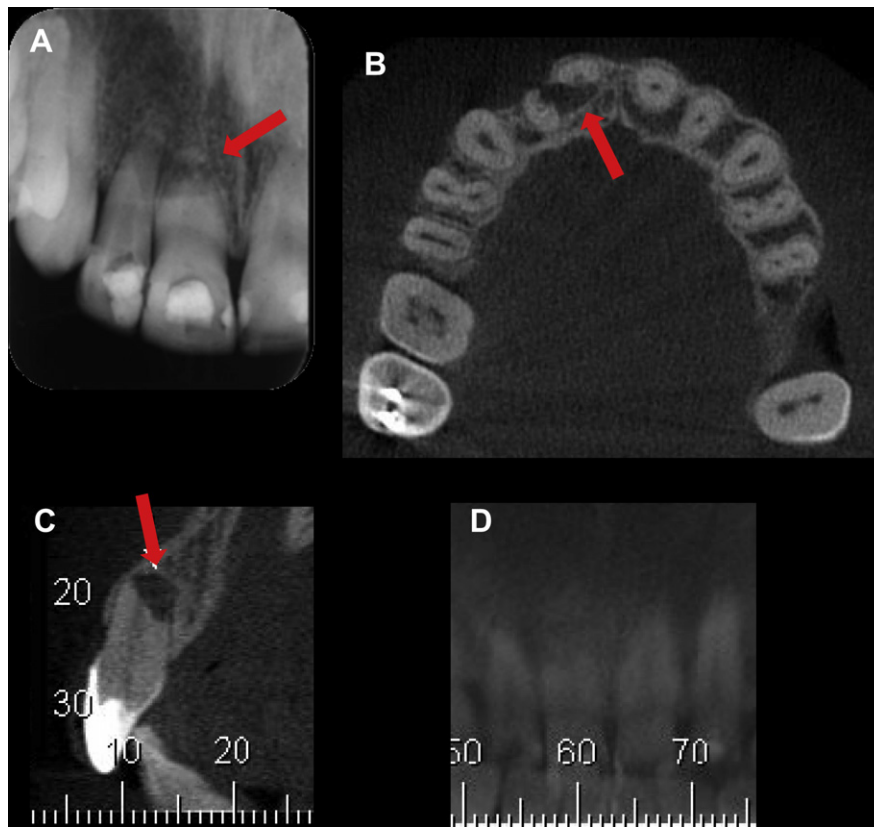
Clinical case of IRR of maxillary central incisor identified by radiography (A) and CBCT in axial (B), transverse (C), and tangent (D) views.
